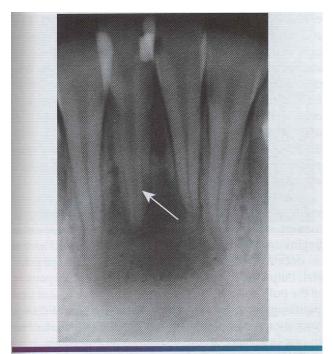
·]. Physiologic secondary dentin. Periapical abscess with all four teeth nonresponsive to electric pulp testing. Increased deposition of physiologic secondary dentin on the right central incisor (arrow) delineated the origin of the infection; endodontic treatment of this tooth resolved the lesion.
